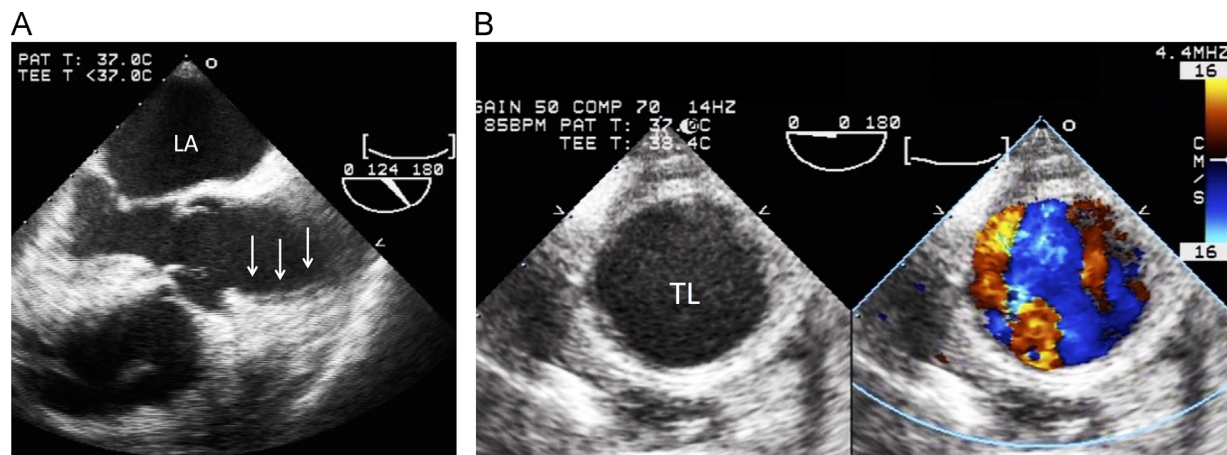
(A) At the second surgery, performed 3 days after the initial surgery, perioperative transesophageal echocardiography indicated a Stanford type-A aortic dissection with a thrombosed false lumen (delineated by arrows), and without any aortic regurgitation, in the midesophageal long-axis view. (B) At the second surgery, performed 3 days after the initial surgery, perioperative transesophageal echocardiography indicated an aortic dissection with a thrombosed false lumen in the descending aortic short-axis view. Abbreviations: LA, left atrium; TL, true lumen.
